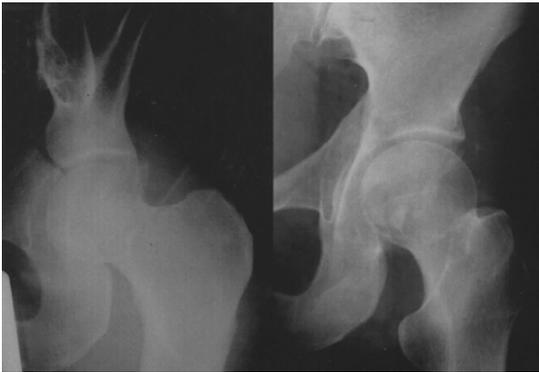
Initial radiographs in a 44-year old woman showing a transverse fracture and posterior wall fracture combined posterior hip dislocation. Skeletal traction is applied after closed reduction.
